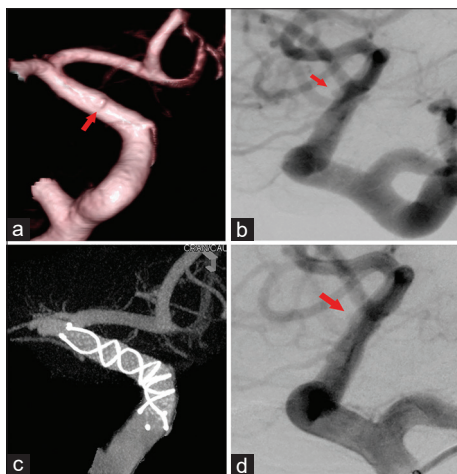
(a) Three-dimensional digital subtraction angiography on day 7 after onset shows *de novo* appearance of a blood-blister aneurysm (arrow) on the anterior wall of the supraclinoid segment of the right internal carotid artery. (b) A *de novo* blood-blister aneurysm (arrow) is present at the working angle on digital subtraction angiography. (c) Cone-beam computed tomography shows that the low-profile visualized intraluminal support stent has been deployed. (d) The blood-blister aneurysm has obliterated on postoperative digital subtraction angiography
